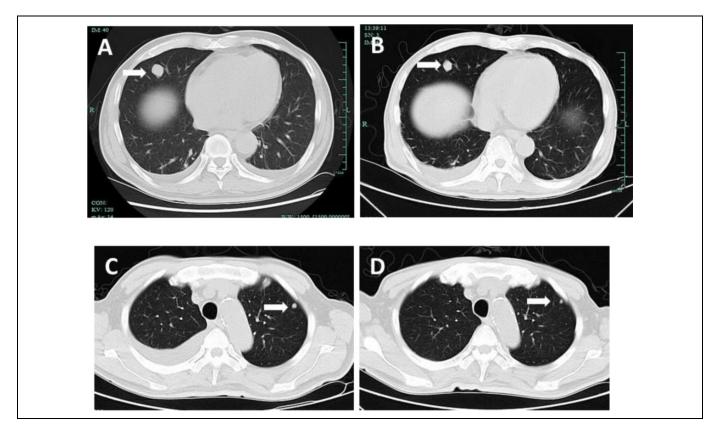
CT images demonstrate the significant reduction in size of lung metastases after treatment. A and C: lung metastases before treatment; B and D: lung metastases after treatment.
